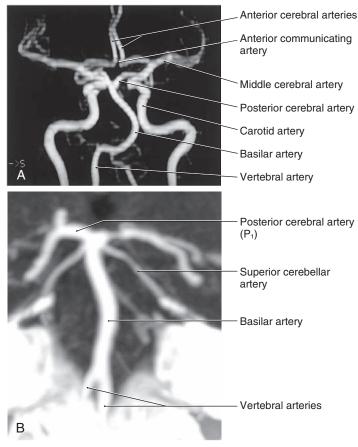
A, MR angiography (MRA) of portions of the internal carotid artery and vertebrobasilar system. B, CT angiography (CTA) of a corresponding view of the vertebrobasilar system. Note that in the CTA image, the initial segment of the posterior cerebral artery (P_1) is constricted in this patient.
